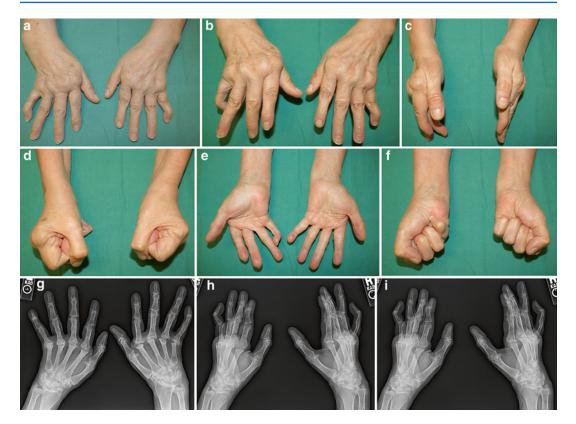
Case #4—Preoperative images and X-rays of a 63-year-old female with a known history of RA and previous silicone arthroplasty
